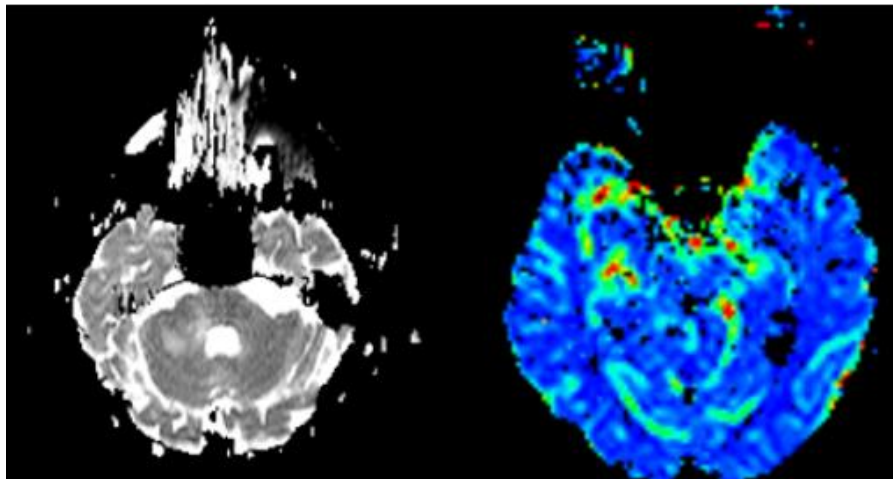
MRI DWI and perfusion in PCNSL
